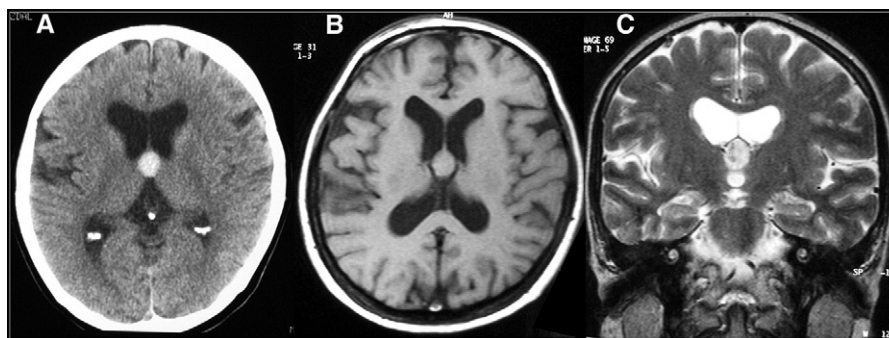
A 44-year-old female patient. (A) There was a 1.5-cm-diameter hyperintense lesion seen within the third ventricle in the neighbourhood of the foramen of Monro on computed tomographic evaluation. The cyst was hyperintense on T1-weighted (B), and isohypointense on T2-weighted images (C).
